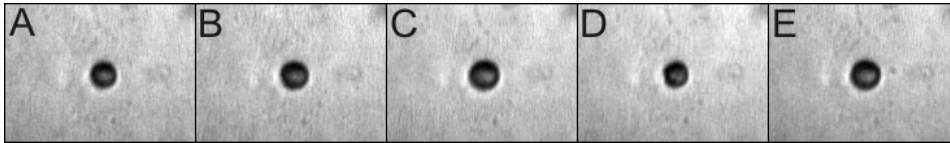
Consecutive images of a contrast agent bubble from the high speed camera Brandaris operated at 14.3 million frames per second (time intervals between images are thus 69.8 ns), during one ultrasound cycle, of frequency 2.6 MHz. The bubble radius is initially 1.95  $\mu\text{m}$ , and frame D shows the bubble compression.
